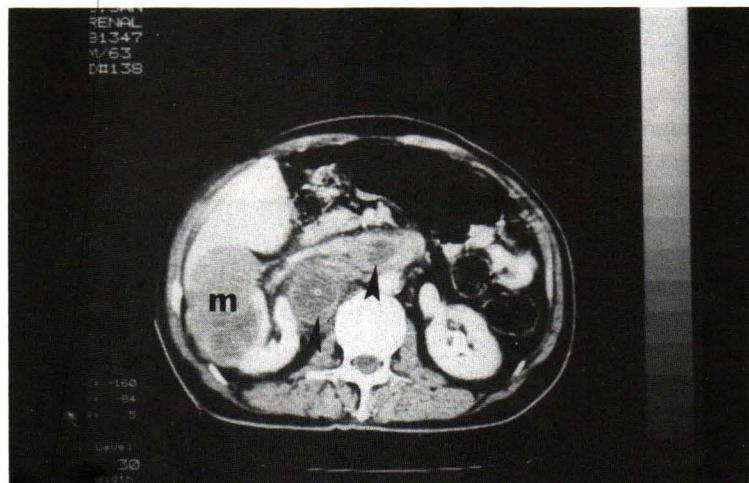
An enhanced axial CT scan shows an inhomogeneously enhanced mass in the right kidney (m); the mass has low-density filling defects (arrow heads) in the renal vein and inferior vena cava, representing a tumor thrombus.
